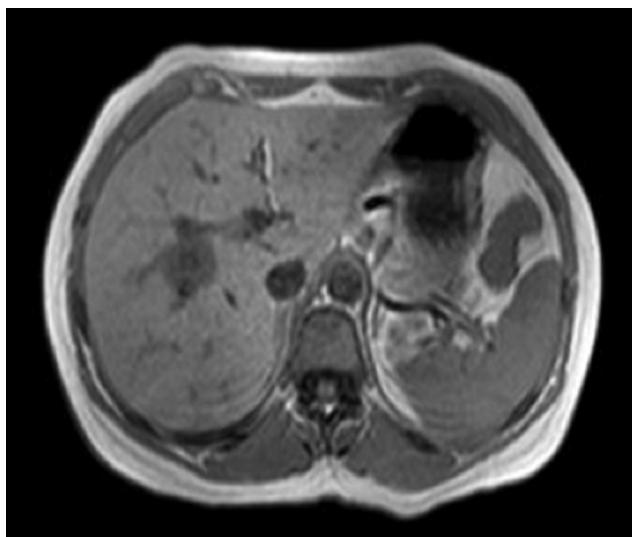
The lesion is hypointense with lower signal intensity in the center on T1-weighted images.
